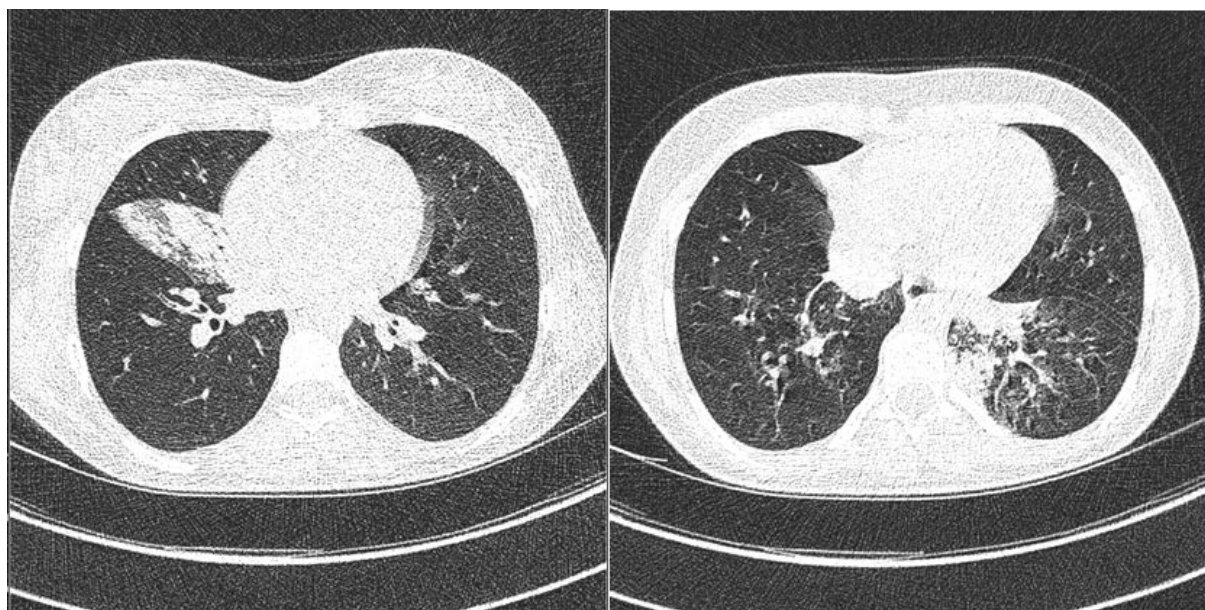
HRCT images at age 10.5
